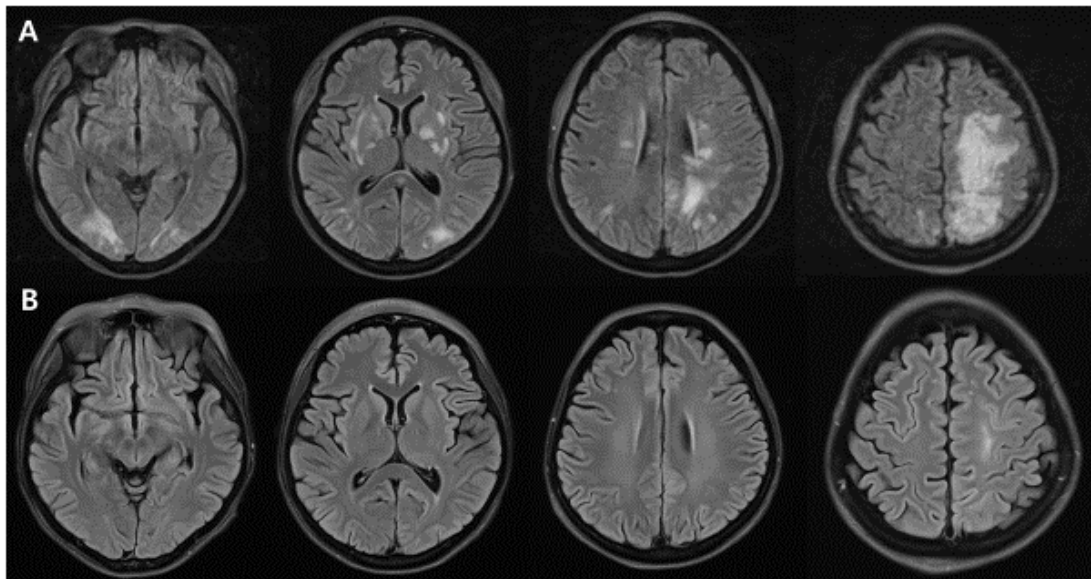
(A) Brain MRI (FLAIR) before and (B) after discontinuation of tacrolimus
